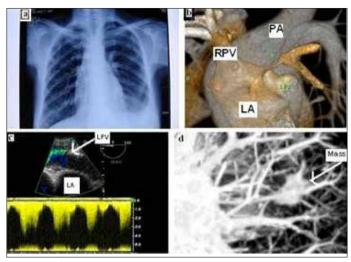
A) Chest radiography view of left sided pleural effusion, B) Computed tomography view of stenosis of upper left pulmonary vein of left atrial wall, C) 2D transesophageal echocardiography apical four-chamber view of high pulmonary venous gradient (36 mmHg), D) Computed tomography; view of a mass in the middle lobe
